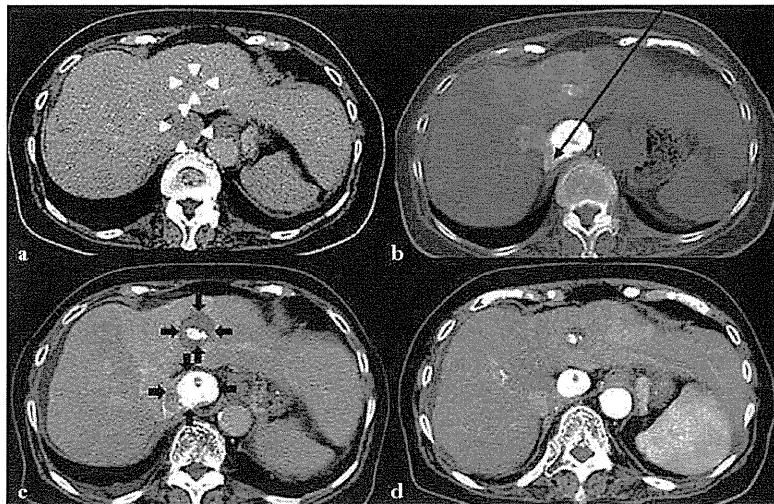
Case 9 (a) Dynamic computed tomography (CT) showed two hepatocellular carcinoma (HCC) lesions 3.0 cm in diameter in the Spiegel lobe and 1.2 cm in diameter in segment 3. An assay for hepatitis C antibodies was positive. (b) Transarterial chemoembolization was performed. (c) Percutaneous radiofrequency was performed five days after chemoembolization. We used the epigastric approach because there were no major vessels in the puncture route. Dynamic CT was performed three days after RFA. The tumor was surrounded by hypo-attenuating non-enhancing areas. (d) No local recurrence has been observed for 13.5 months after RFA.
